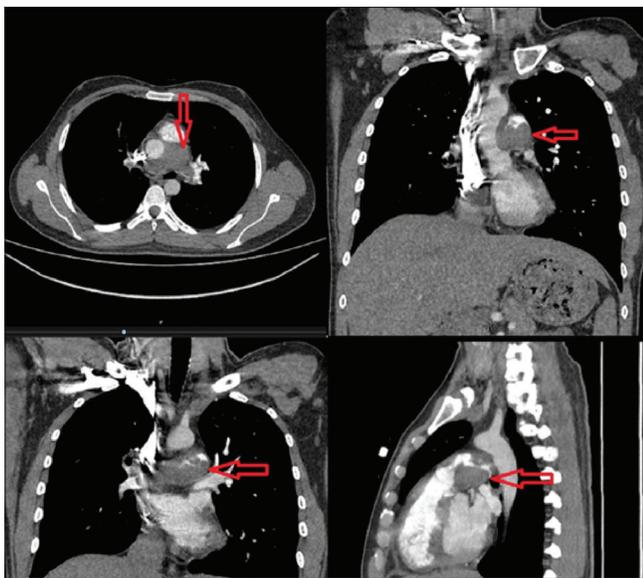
A computed tomography angiography scan with different axes displayed a massive pulmonary thromboembolism; note that red arrow shows nearly complete obliteration of the main pulmonary artery
